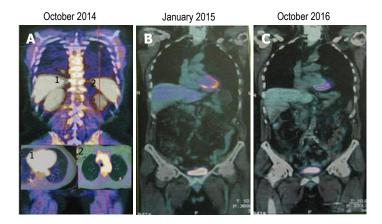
Positron emission tomography/computed tomography restaging after panitumumab-based therapy. A: Positron emission tomography/computed tomography scan revealing two lung metastases; B: Complete response after 6 cycles of Folfiri/Panitumumab; C: Long-lasting complete response after maintenance therapy with panitumumab single agent.
